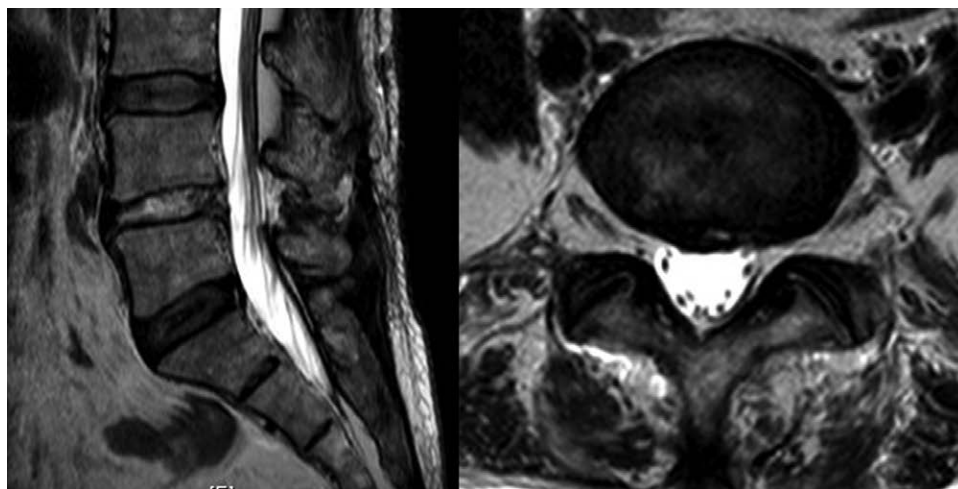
MRI negative case. A patient with a herniated lumbar disc underwent partial hemilaminectomy and discectomy. Upon immediate, postoperative MRI, there were no abnormal findings to explain his symptoms. MRI = magnetic resonance imaging.
